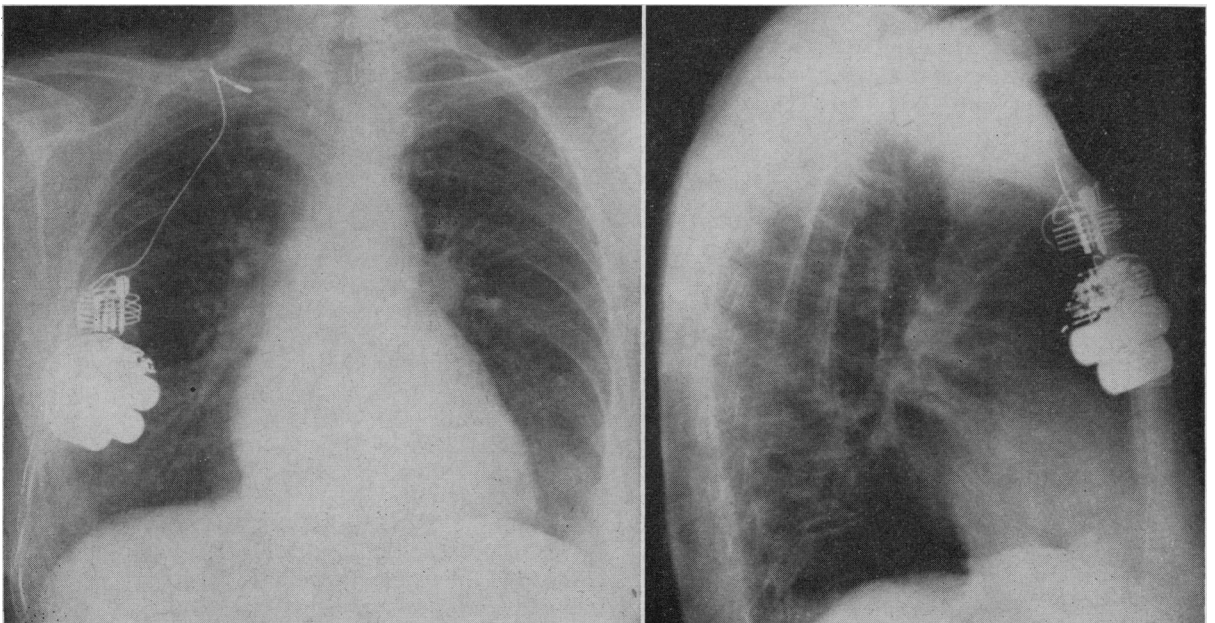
Radiograph of chest showing transvenous lead coiled around pacemaker boot and electrode retracted into the neck.
